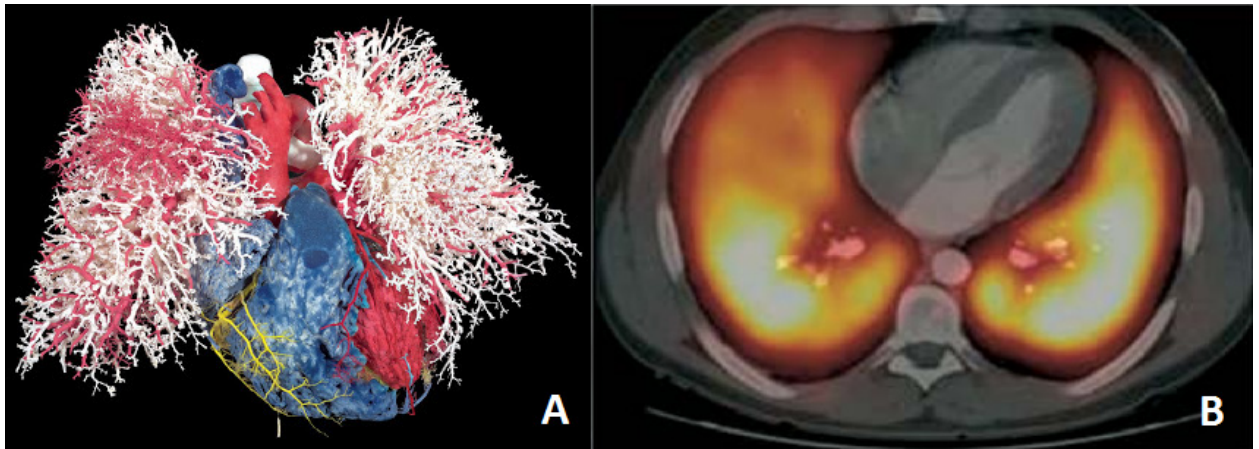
A: Lung corrosion cast showing vasculature (41), and B: Lung perfusion SPECT with ^{99m}Tc -MAA (42)
